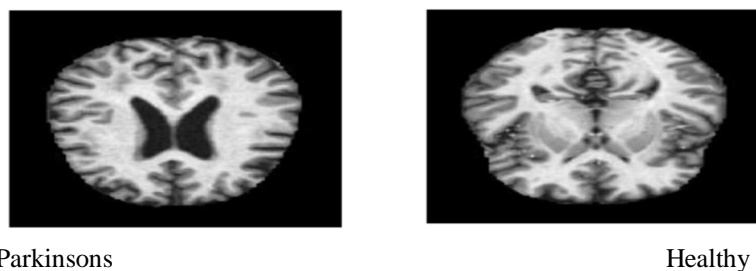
MRI scans of healthy and Parkinson's patients (adapted from [2]).
